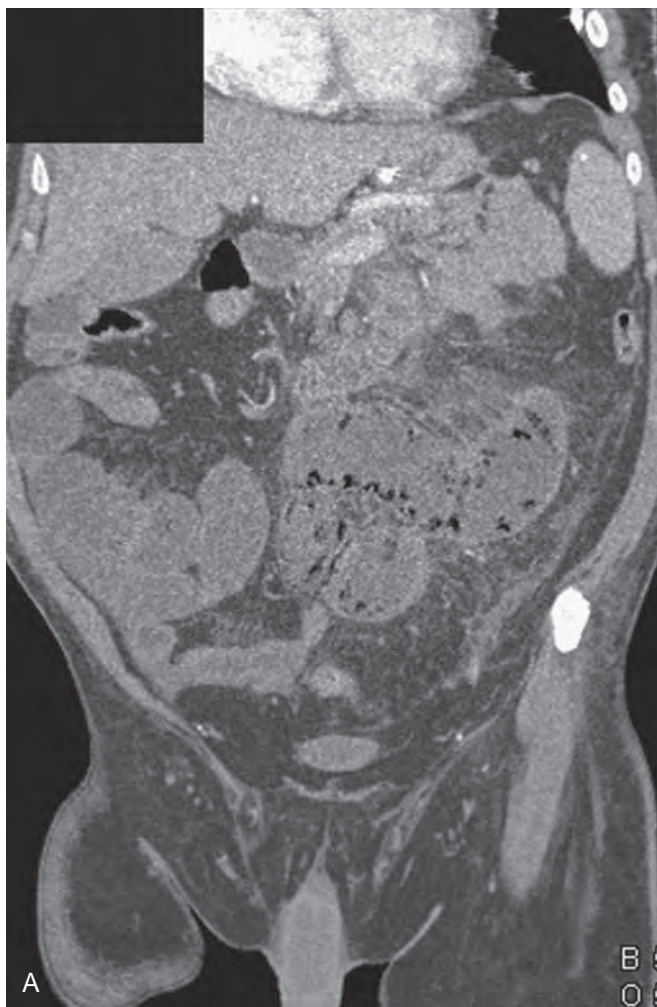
Superior mesenteric artery thrombosis: contrast-enhanced CT images in a patient with acute abdominal pain. A. Coronal contrast-enhanced CT image demonstrates dilated small bowel loops in the mid and right abdomen, with pneumatosis identified within several small bowel loops, predominantly in the central abdomen. B. Axial contrast-enhanced CT image demonstrates subtle thrombus (arrow) in the superior mesenteric artery. Multiple small bowel loops are dilated with thin walls (no appreciable bowel wall thickening) and a small amount of adjacent ascites, findings that raise concern for bowel ischemia. C. Volume-rendered contrast-enhanced image in the sagittal projection demonstrates a large thrombus (arrow) in the superior mesenteric artery, the full extent of which was not appreciated on the axial image. D. Volume-rendered contrast-enhanced CT image in the sagittal plane after surgical embolectomy demonstrates a patent superior mesenteric artery.
